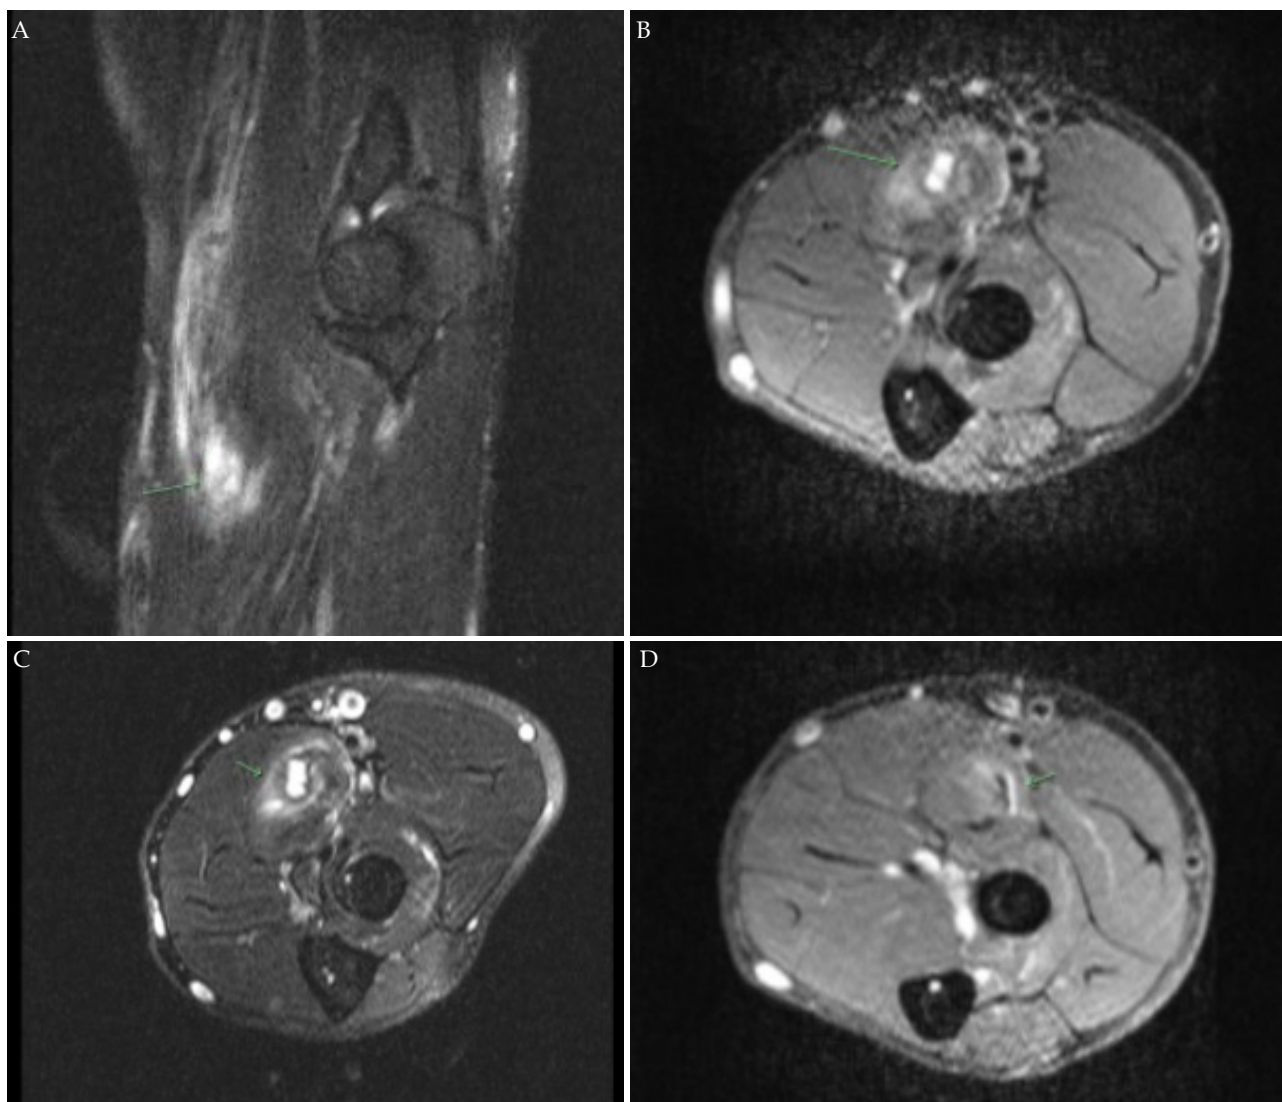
2D: MRI imaging of pronator teres tear highlighted as increased intensity on sagittal and axial images.
